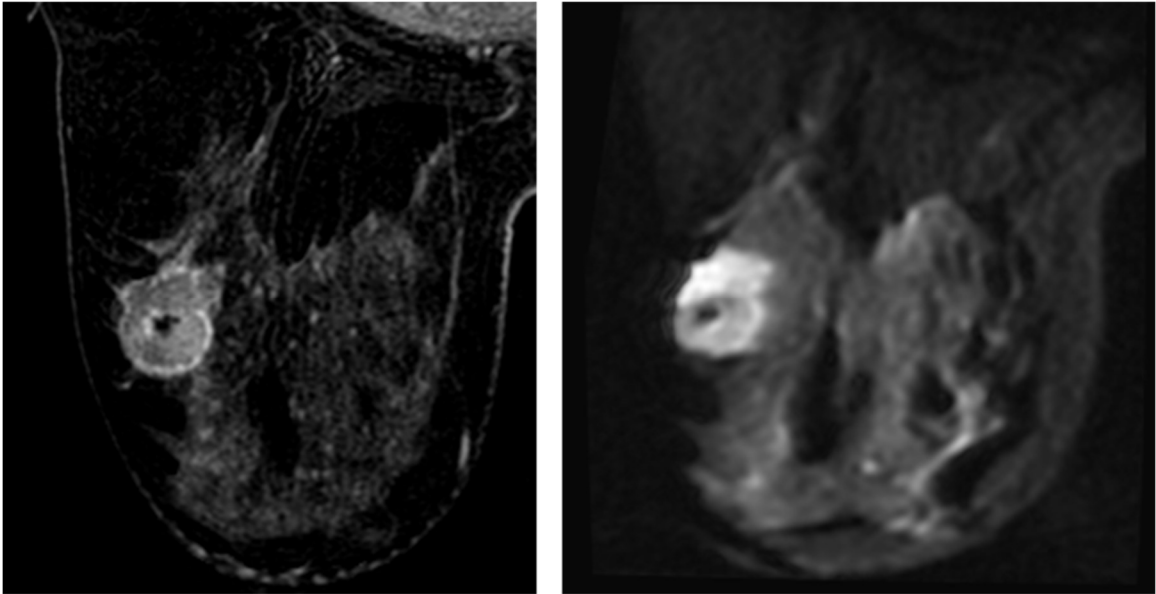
Example of contrast-enhanced spoiled GRE MRI (left) compared with SE-ssEPI diffusion MRI (right) in a 40-year-old woman with TNBC in her left breast. Distortion of the tumor and fibroglandular tissue can be seen. This EPI image has already undergone geometric correction by the vendor, as is evident in the uneven boundary on the left of the image.
